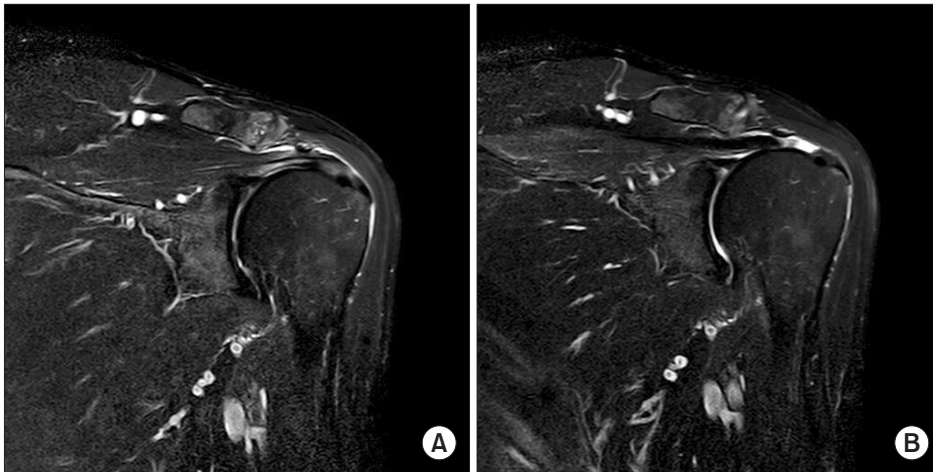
(A) Initial oblique coronal magnetic resonance imaging (MRI) section (T2 fat suppression). (B) Final oblique coronal MRI section (T2 fat suppression) at the 5-year follow-up shows an elongated supraspinatus tendon tear.
